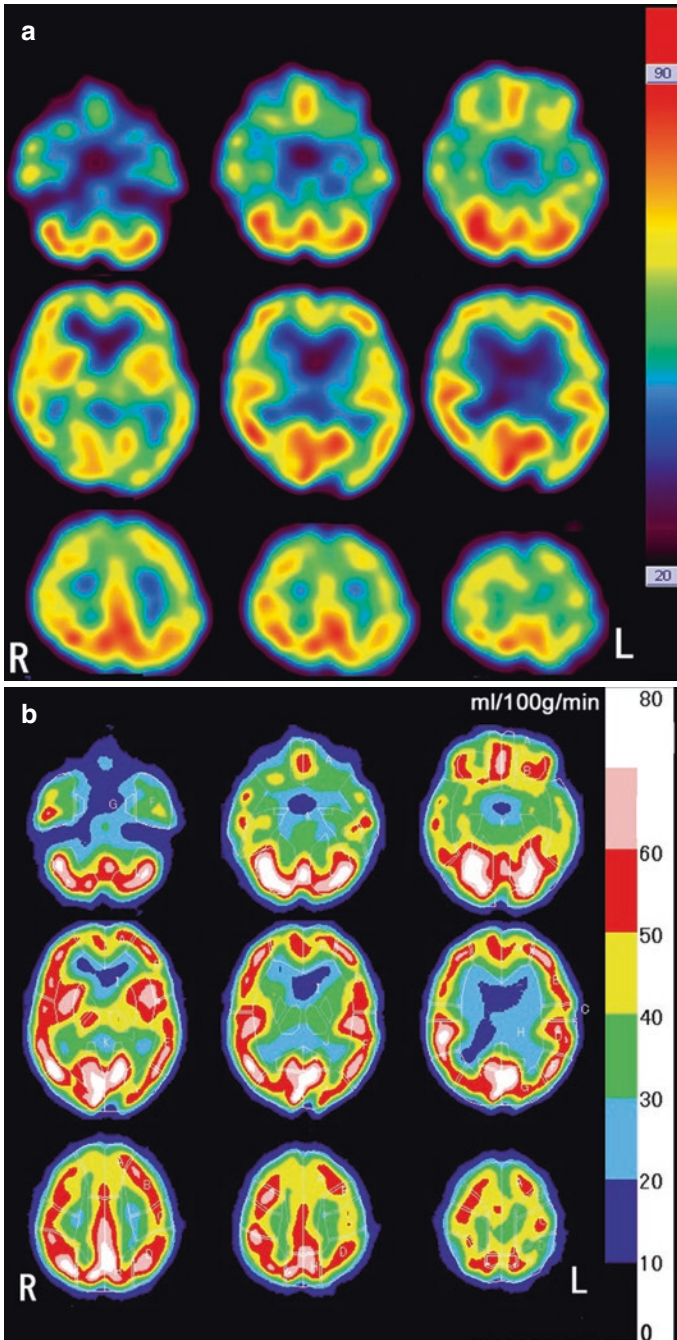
Conversion of original ^{99m}Tc -ECD SPECT to rCBF SPECT images. (a) Original SPECT images. (b) rCBF SPECT images
